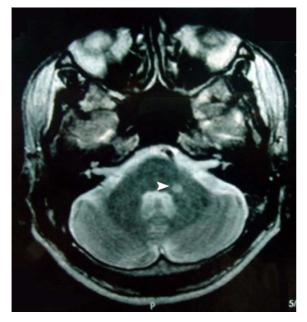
Axial T2-weighted MR image shows lesion in left cerebellar peduncle
